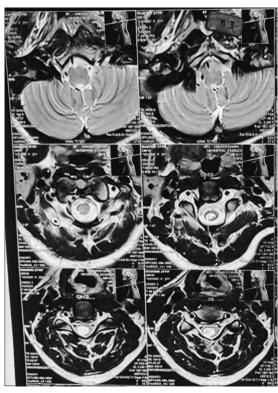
Magnetic resonance imaging of the base of the brain suggestive of syringomyelia and Chiari malformation
